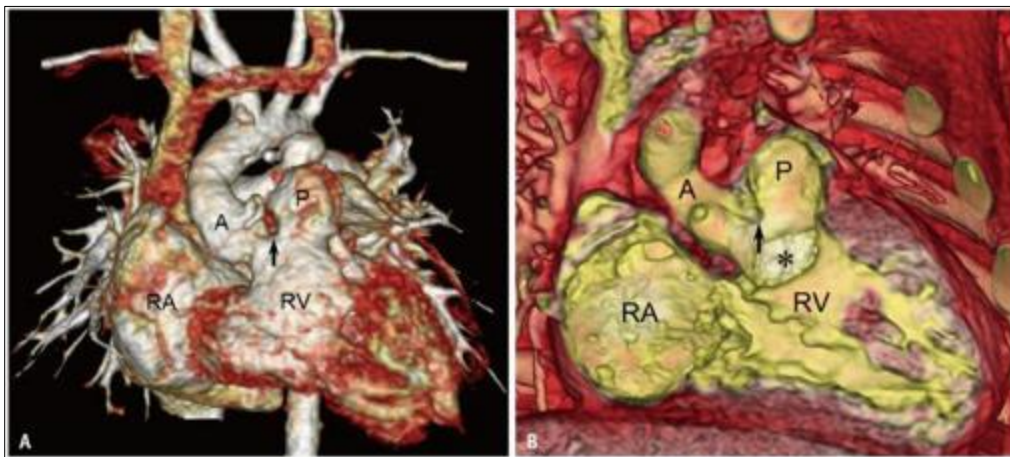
Double outlet RV with doubly-committed VSD in an infant. A, B. Standard (A) and transparent-lumen (B) volume-rendered CT images show that both great arteries are connected to the morphologic RV. The outlet septum (arrows) is fibrous, characteristic of a doubly committed VSD (asterisk). A = ascending aorta, P = pulmonary artery, RA = right atrium, RV = right ventricle, VSD = ventricular septal defect
